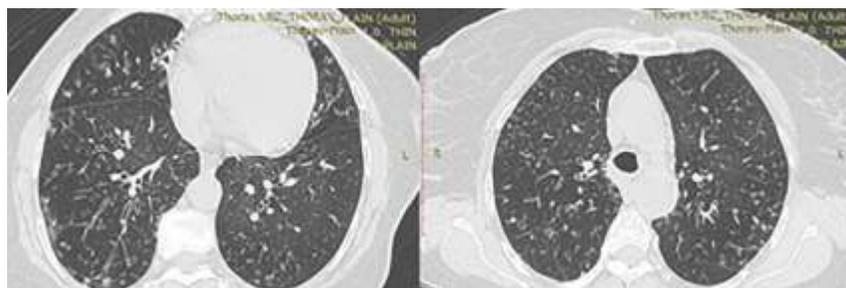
HRCT Thorax showing Bilateral Diffuse Centrilobular Nodules and Bronchiectasis
